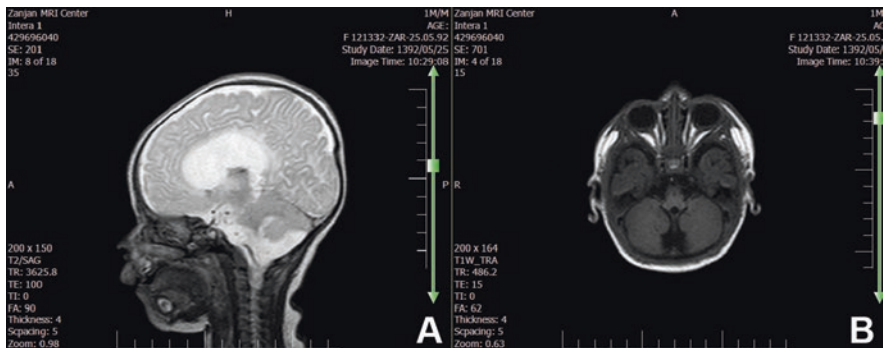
Dandy–Walker malformation. (a) Sagittal T2-weighted brain MR image showing hypoplasia of the inferior vermis. A connection between the cisterna magna and the fourth ventricle is seen. (b) Axial T1-weighted brain MR image showing a cerebellum with isolated inferior vermian hypoplasia and normal cerebellar hemispheres, which is referred to as part of the Dandy–Walker variant
